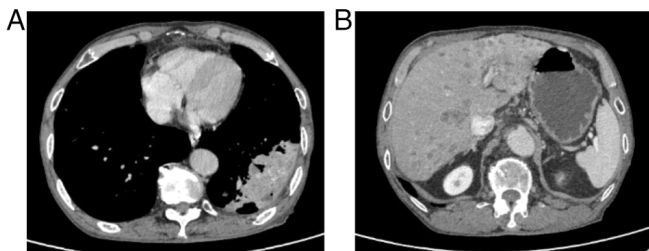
Computed tomography scans showing (A) the left lower lobe mass decreased to a maximum diameter of 8.4 cm. (B) Multiple liver metastases decreased, some completely disappearing.
